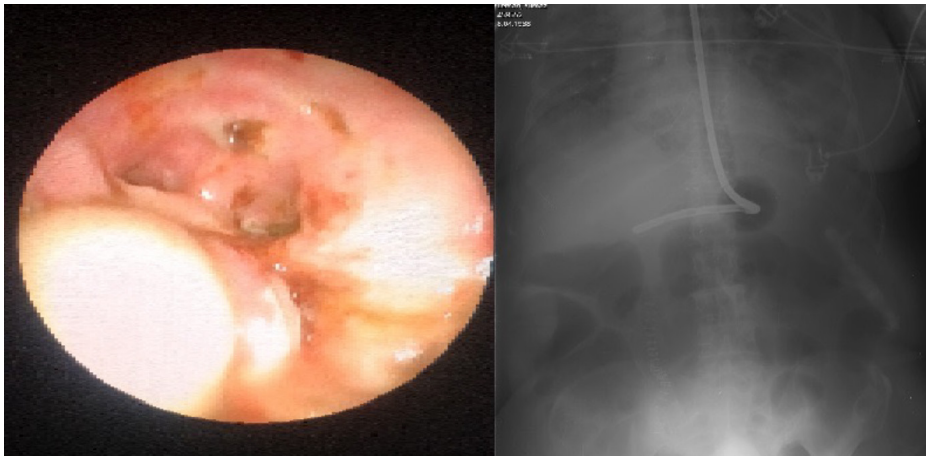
Bronchoscopy and posteroanterior chest radiography after Sengstaken–Blakemore tube.
